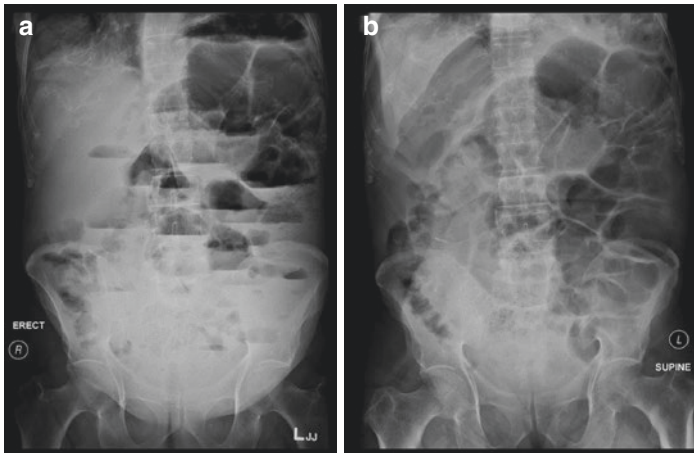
Upright and supine abdominal radiograph with features suggestive of SBO. (a) Erect radiography exhibiting stepwise air-fluid levels characteristic of SBO with a paucity of colonic gas. (b) Supine radiography demonstrating distended loops of bowel with fecalization
